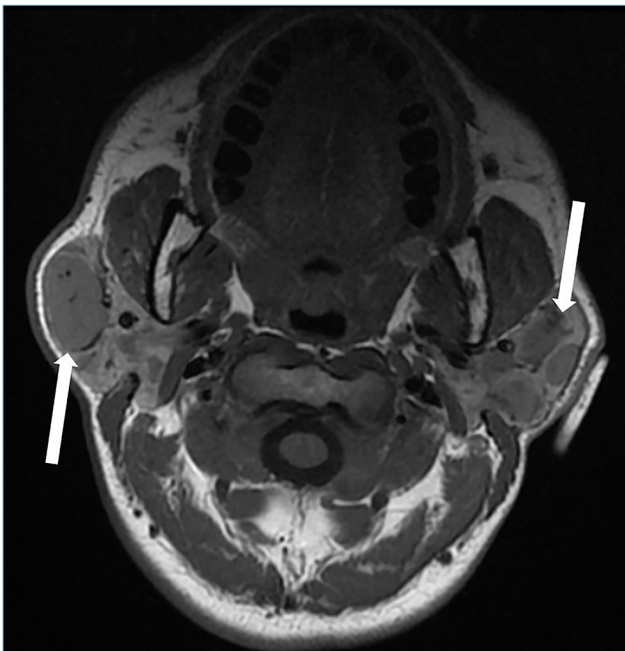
Preoperative MRI: axial T1-weighted image shows bilateral multiple hypointense nodules (white arrow) in the parotid glands.
